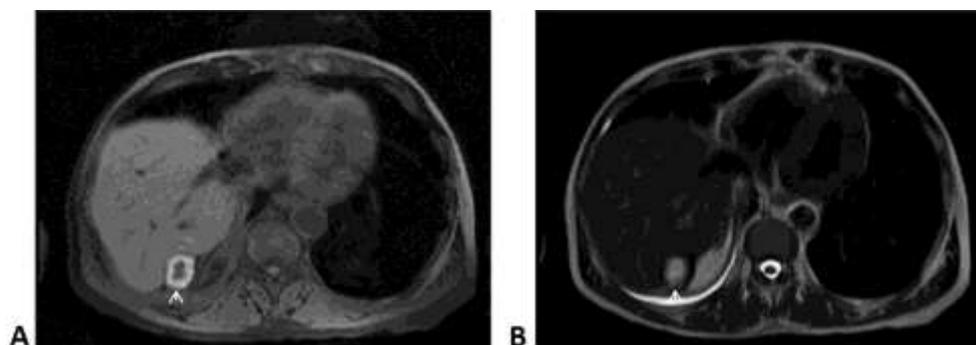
A and B. Axial T1 fat-saturated and T2-weighted images demonstrate a complex fluid collection (*arrowheads*) within Morrison's pouch. Note the rim of increased signal intensity on T1-WI with decreased signal intensity on T2-WI, most consistent with a hematoma.
